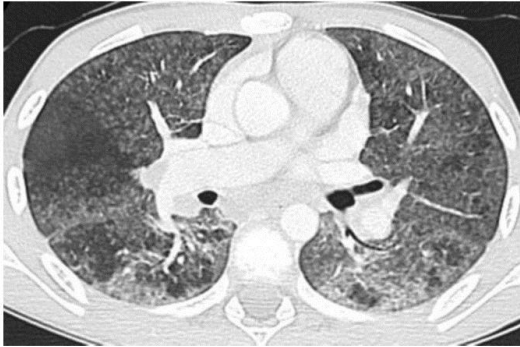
High resolution CT on lung window demonstrates a mosaic pattern with diffuse fine centrilobular nodules and a ground glass appearance in the dependent areas consistent with an acute hypersensitivity pneumonitis.
